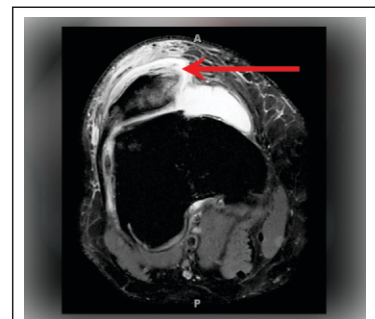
Medial patellofemoral ligament injury can be visualized on axial magnetic resonance imaging images with increased signal and disruption of the medial retinacular structures (arrow).
